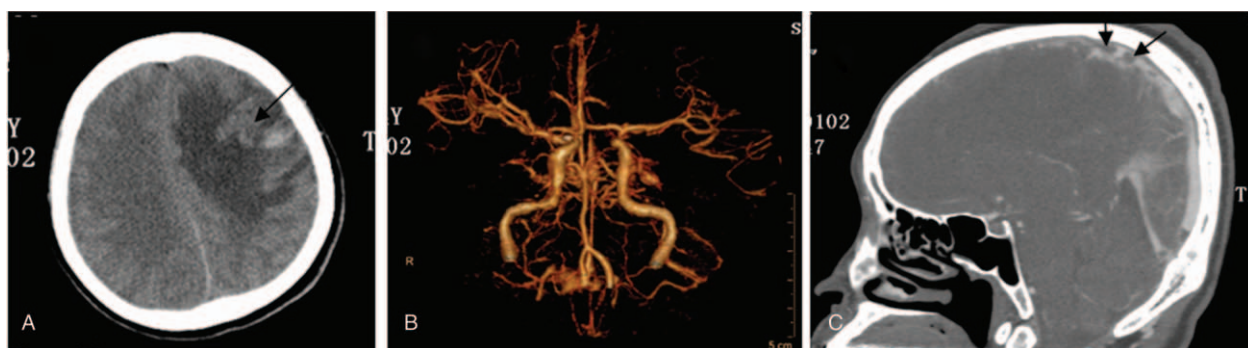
The high-signal image of the computed tomography scan shows ischemia and hemorrhage in the left frontal lobe (black arrow, A); no abnormality in cerebral arteries (B); and sinus thrombosis observed in the superior sagittal sinus by computed tomography venography (black arrow, C).
